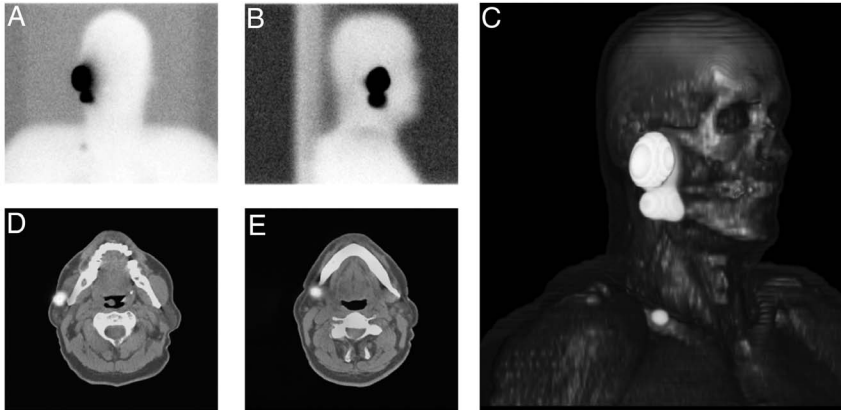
A 62-year old man with a pre-auricular melanoma. Conventional images (A, B) show a sentinel node caudal from the injection area and a second-echelon node near the clavicle. The three-dimensional reconstruction of the single photon emission computed tomography with computed tomography (SPECT/CT; C) shows a cluster of two radioactive nodes in relation to the injection area and the mandible. Two-dimensional SPECT/CT fusion images (D, E), clearly show one sentinel node at the mandibular angle and another one located more ventrally, just caudal from the mandible. This latter node was tumour-positive.
